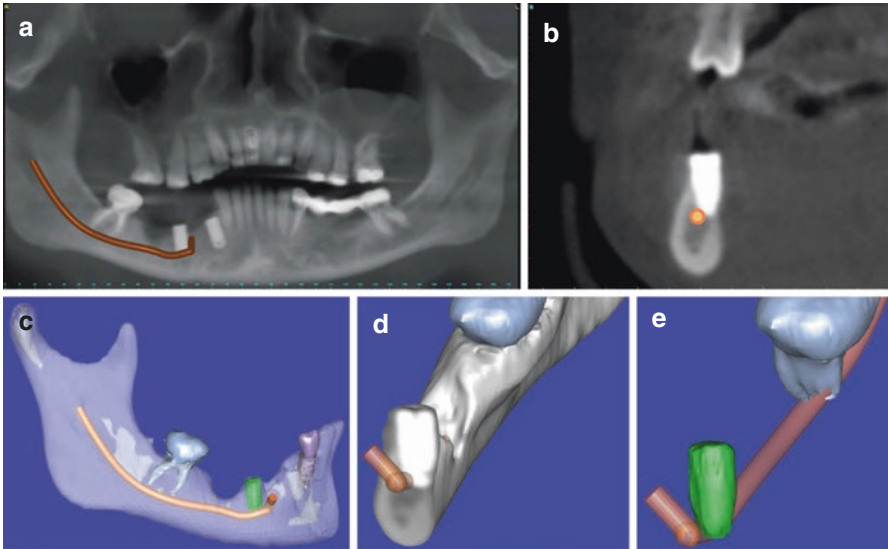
(a) CBCT generated panoramic radiograph with right inferior alveolar canal in proximity to #29 dental implant; (b) Coronal slice of the same patient demonstrating #29 dental implant impingement on the right inferior alveolar canal; (c) 3D reconstruction with transparency of the osseous structures; (d) Cross-section of 3D reconstruction; (e) Osseous structures removed from previous image. Miloro M: Trigeminal Nerve Injuries, Fig. 6.6, p. 95
